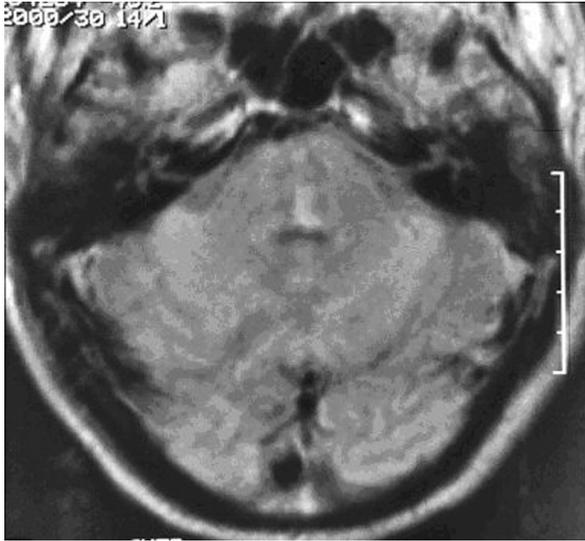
A left pontine tegmental infarction (MRI T2-weighted imaging).
